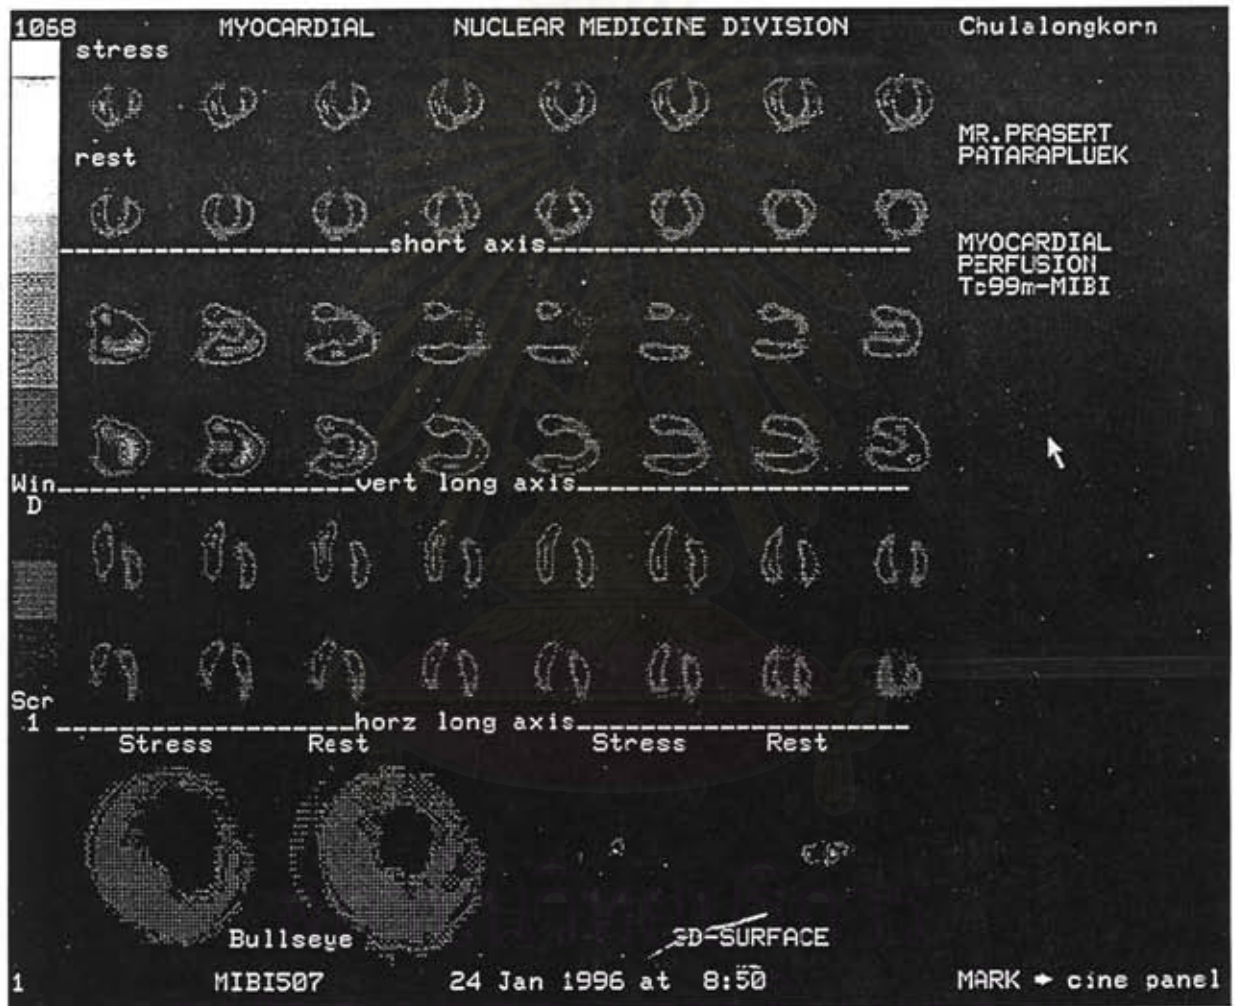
Tc-99m Sestamibi SPECT images before PTCA from a 73 year male patient with a reversible filling defect (myocardial ischemia) at anterior and apical wall corresponding to a significant left anterior descending artery (LAD)
